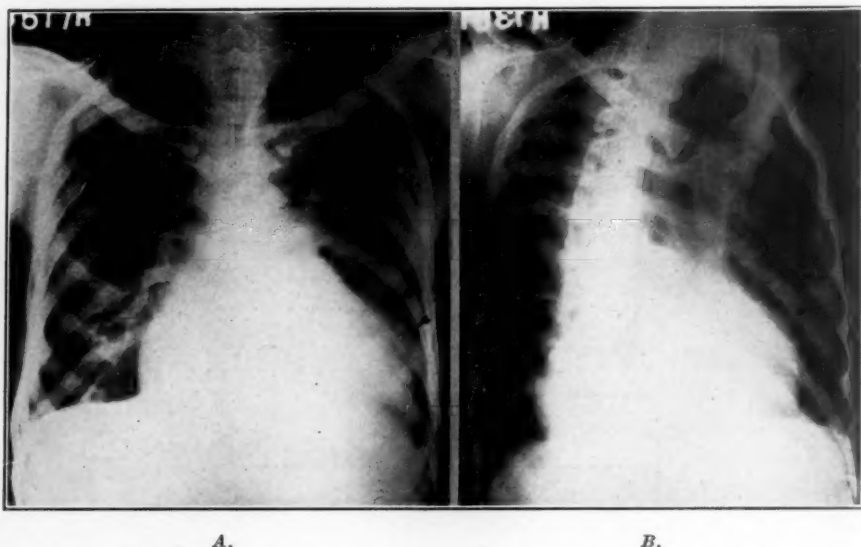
A, Case 1. Teleoroentgenogram showing enlargement of the heart to the left, with blunting of the apex. Typical of diffuse cardiac aneurysm. B, Case 1. Right anterior oblique roentgenogram, revealing a diffuse bulge of the left ventricular border with typical angulation. Presence of aneurysm confirmed by necropsy.
